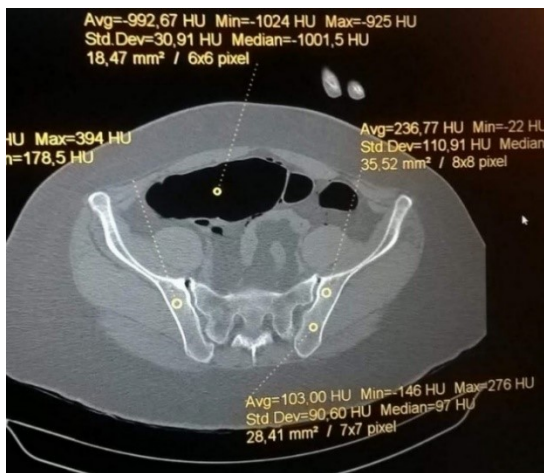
A clinical CT scan with average HU of selected sites. With permission of the Department of Radiology, Faculty Hospital in Hradec Králové.
